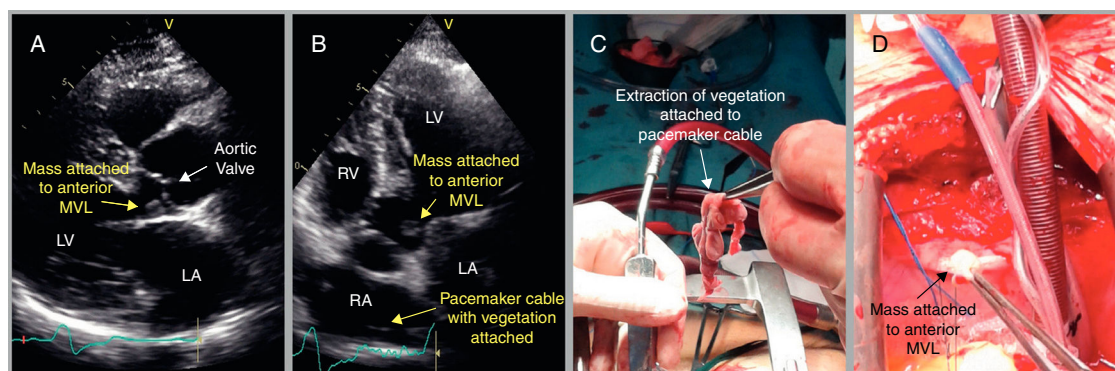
(A,B) 2D echocardiographic (C,D) large vegetation attached to pacemaker cable.
